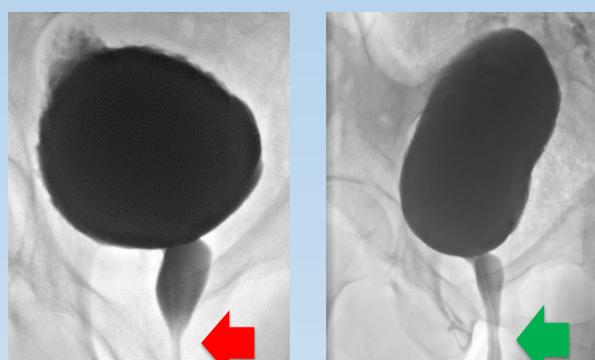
Radiographic example of micturition before and after Botox[®] injection
